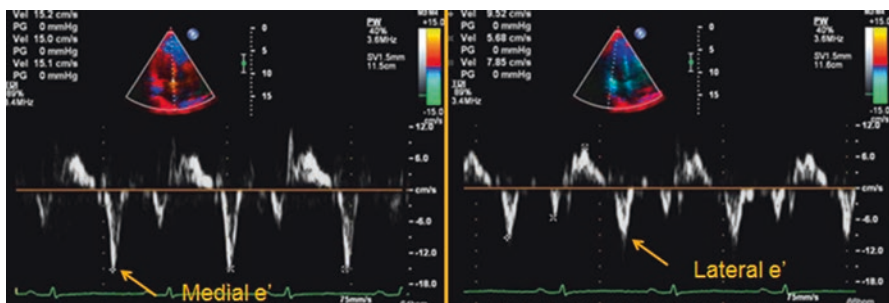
Annulus reversus in constrictive pericarditis. Medial (left) and lateral (right) mitral annular tissue Doppler recording (apical window) in a patient with constrictive pericarditis. There is normal to increased early relaxation velocity (e'), with medial velocity (e' 12 cm/s) greater than lateral (e' 6 cm/s). Reproduced with permission from [13]
